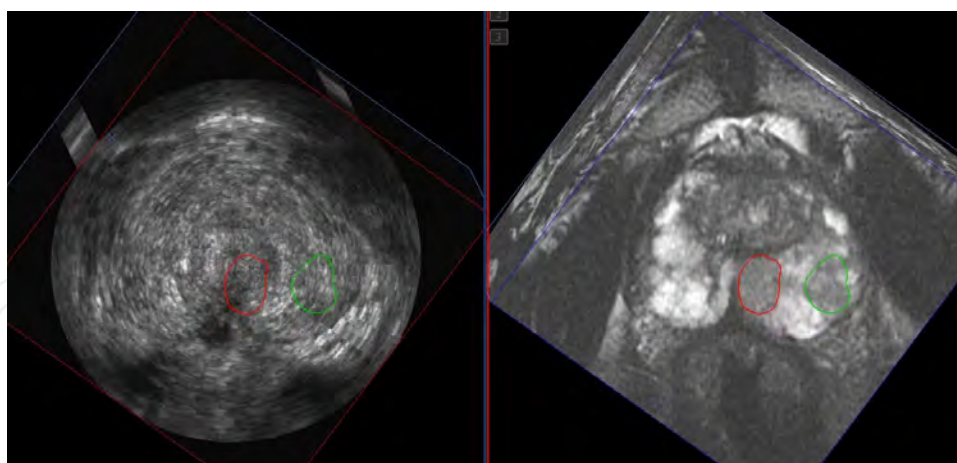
Registered 3D TRUS and MRI images of the same patient showing delineated suspicious lesions identified in the MR images (right panel). The MR images were then registered with the 3D TRUS images (left panel) and the delineated two regions (red and green) superimposed on the 3D TRUS images. These regions were then targeted with the 3D TRUS-guided biopsy system shown in Figs. 8 and 9.
